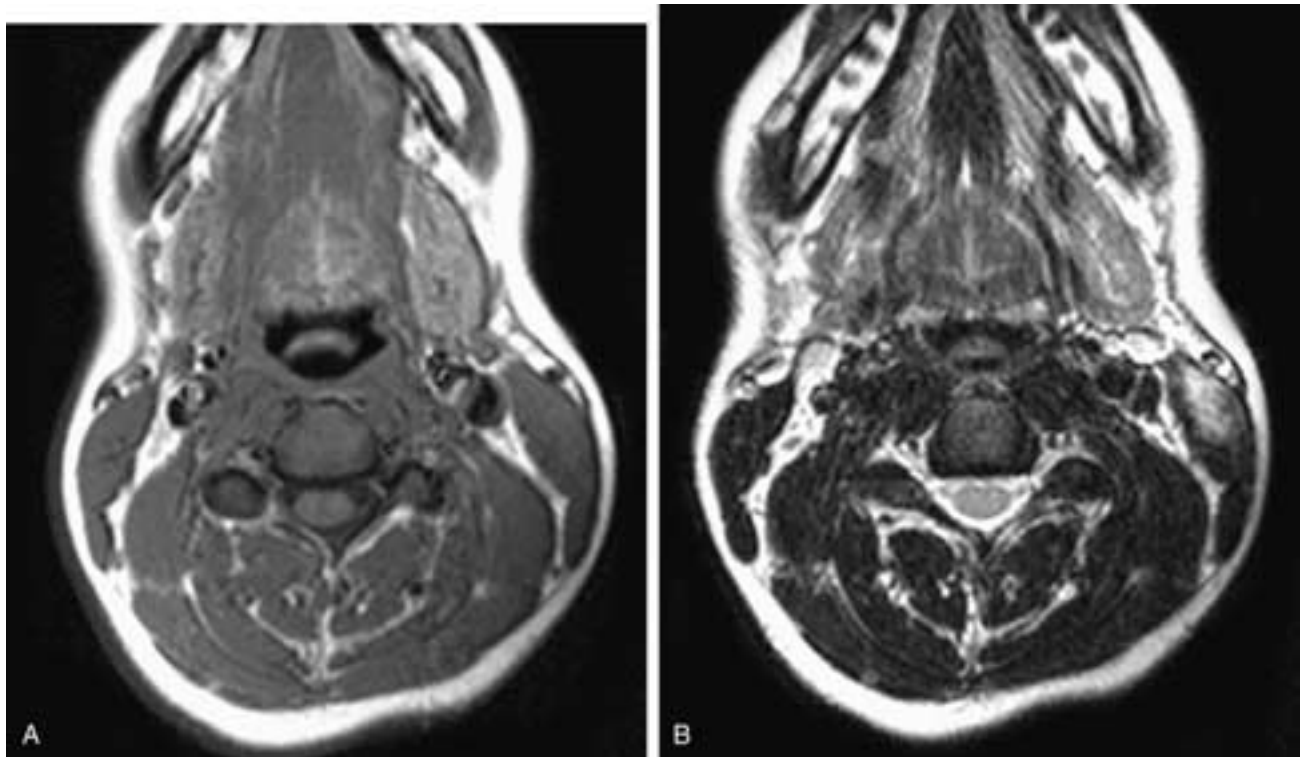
Axial T1-weighted (A) and T2-weighted (B) MR images show minimal thickening of the anterior left sternocleidomastoid muscle and an area of high T2-weighted signal intensity. This patient had a left submandibular gland acute sialadenitis with a cellulitis. He was treated with antibiotics, and although the other signs of infection subsided, he had persistent muscle pain in his sternocleidomastoid muscle. This was an inflammatory myositis.
